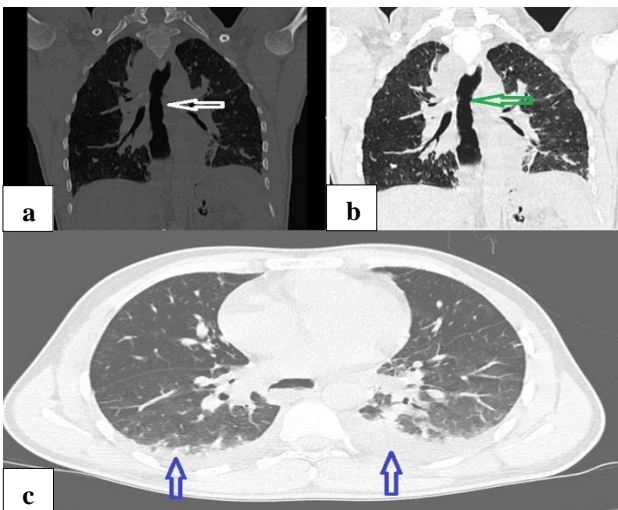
Computed tomography showing aspiration pneumonia changes with the normal esophagus (green arrow) with bilateral minimal pleural effusion (blue arrows) without evidence of pneumomediastinum and no evidence of any air foci around the esophagus (white arrow), (a) and (b) coronal sections, and (c) axial section.
